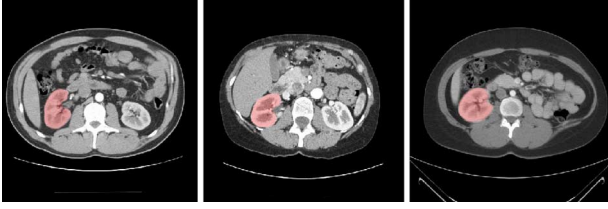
Training set: right kidney masks in three CT images (red regions).
